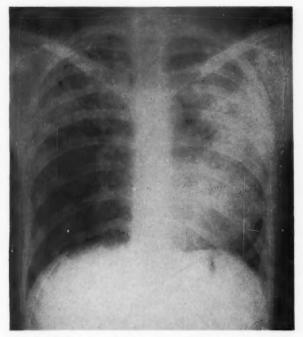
G. B., a twenty-seven year old man. X-ray of the chest shows extensive infiltration in left lung, infiltration in upper half of right lung and large cavity.
